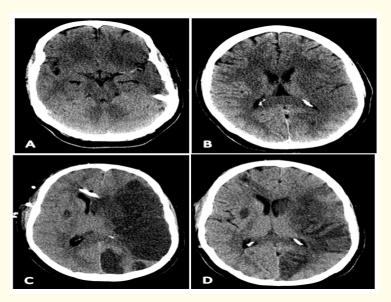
Plain CT brain; day 1 (A and B) shows hyperdense left MCA sign with early ischemic changes. Follow up CT brain at day 3 (C) shows well established non-hemorrhagic acute infarction in left MCA territory with mass effect. There are additional findings of acute infarctions in the left PCA territory and right basal ganglia (which was not obvious on baseline scan). CT brain at day 10 (D) shows resolving stroke and its mass effect.
